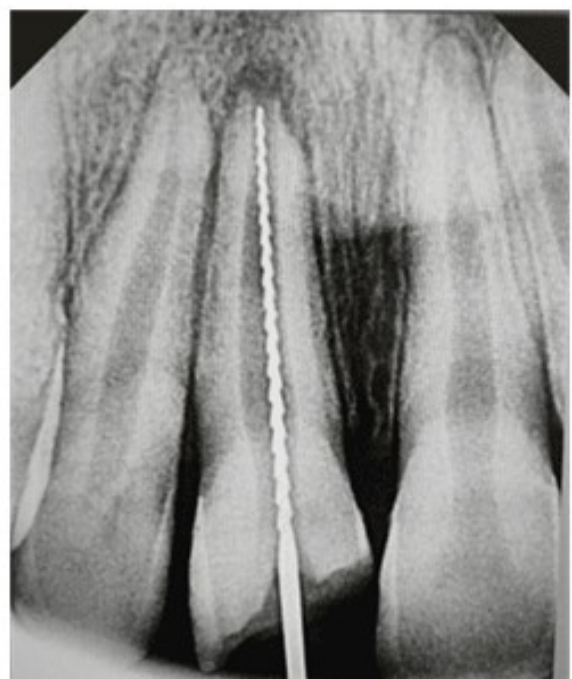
Working length radiograph of 11
